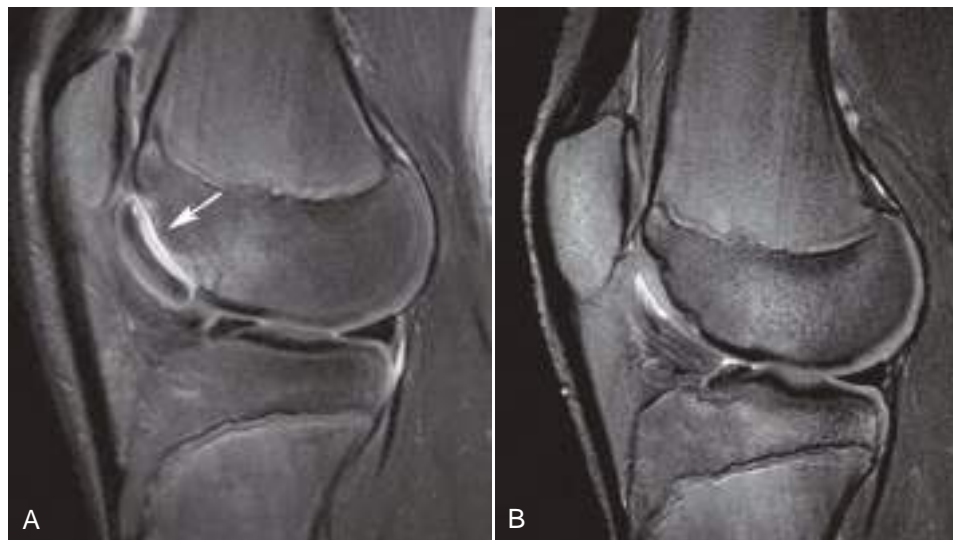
Osteochondral fracture with successful repair. (A) Sagittal fat-suppressed T2-weighted fast spin-echo MR image (echo time, approximately 45 msec) shows a detached lateral femoral trochlea osteochondral lesion (*arrow*). (B) Follow-up MR study performed several months after surgical fragment reattachment shows successful repair, with healing of the bone fragments and smooth articular cartilage contour.
